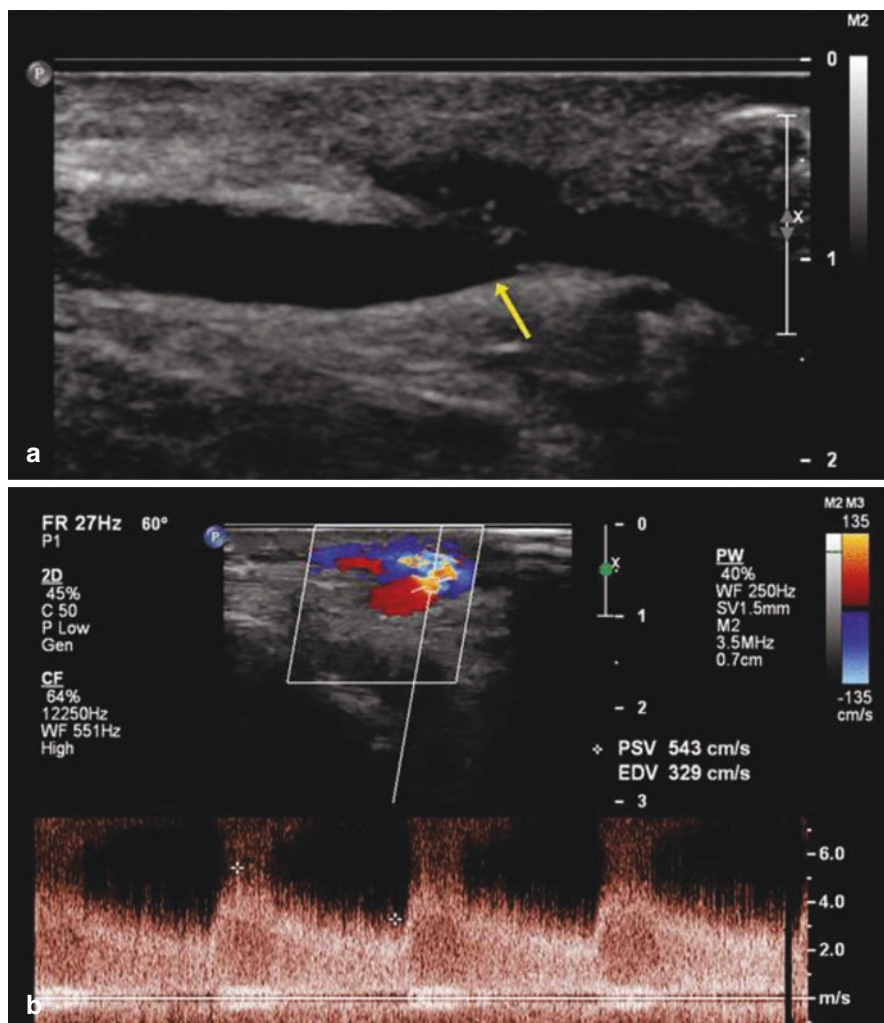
(a) Grayscale ultrasound demonstrates juxta-anastomotic stenosis (*arrow*) of the radial artery. (b) Color Doppler ultrasound at the same location demonstrates increased velocity at the site of stenosis consistent with hemodynamically significant stenosis of the radial artery
